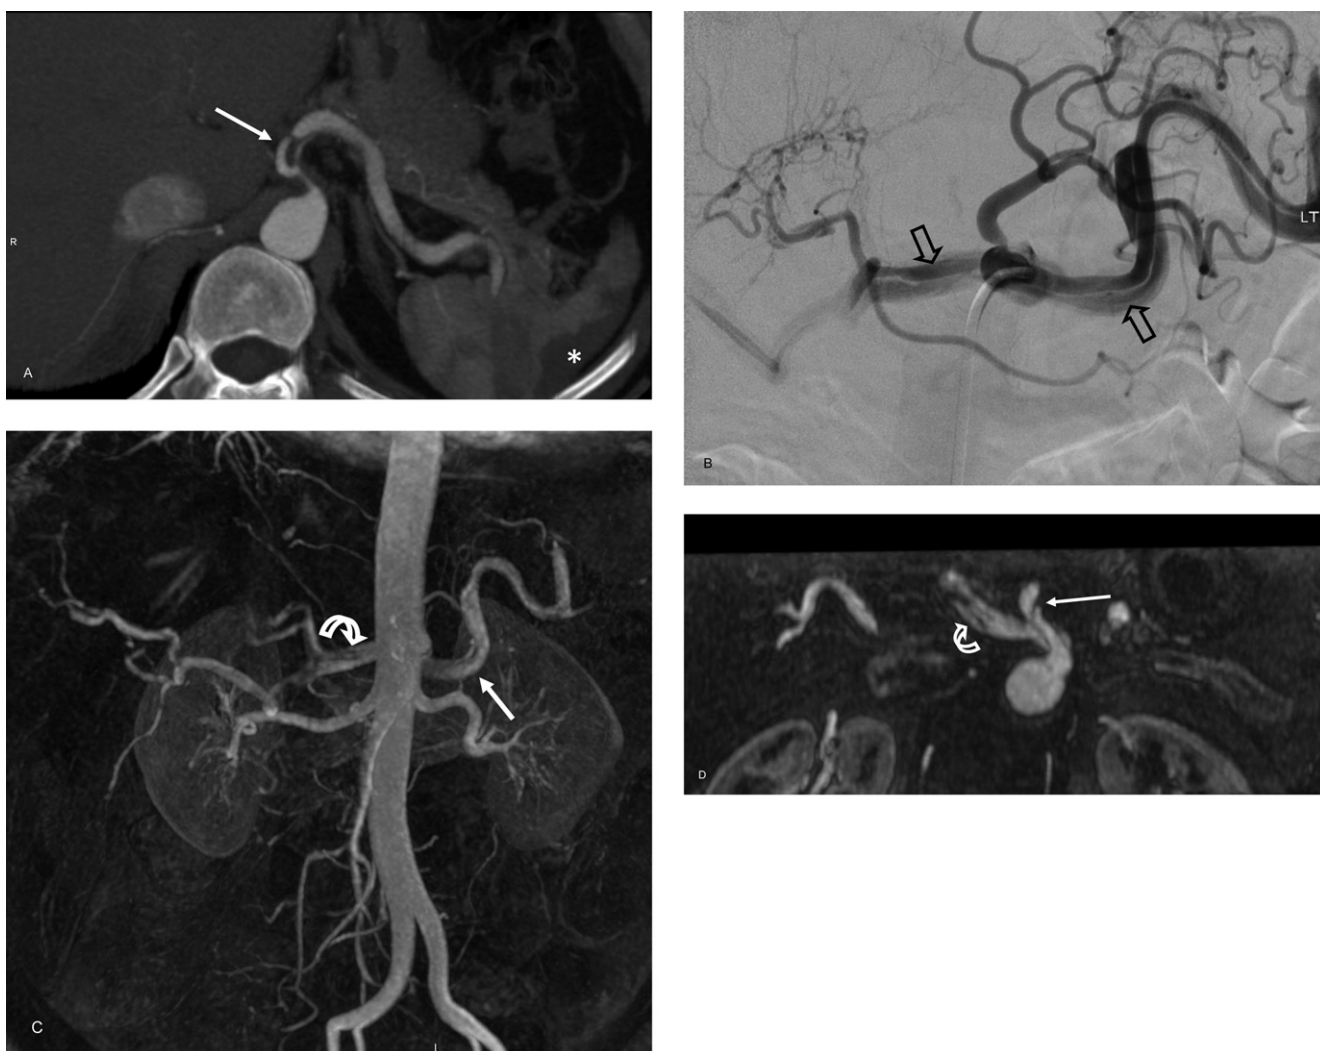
A 44-year-old man with a diagnosis of Ehlers-Danlos syndrome presented to emergency department with chest pain radiating down to the abdomen. (A) CTA shows dissection of the celiac trunk and partial thrombus within the false lumen (arrow). Note the wedge-shaped perfusion defect in the spleen (*). (B) Elective CA for peripheral vascular evaluation confirms the evidence of celiac trunk dissection as well as splenic and common hepatic artery involvement seen as a lucent line in the contrast within the artery (open arrows). (C) Coronal and (D) axial MIP images obtained from the follow-up 3D Gd-MRA also successfully demonstrate the extension of the dissection into common hepatic (curved arrow) and splenic arteries (straight arrow).
